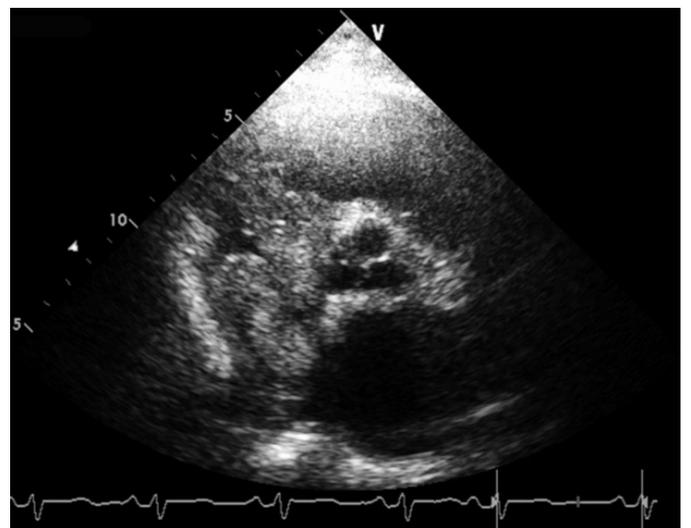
Parasternal short axis view showing thrombus moving to and fro into the right ventricle.
